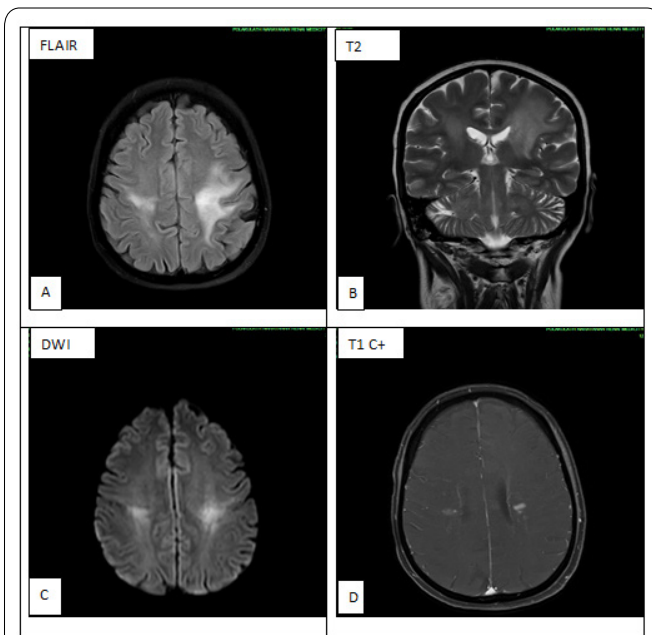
Follow up MR image of brain done after 4 weeks. FLAIR axial A- and T2 coronal images B- show increase in the extent of supratentorial white matter lesions. Diffusion weighted axial image C- shows moderate diffusion restriction over the corresponding areas. Post contrast axial sequence D- showing bilateral nodular and linear foci of enhancement.
